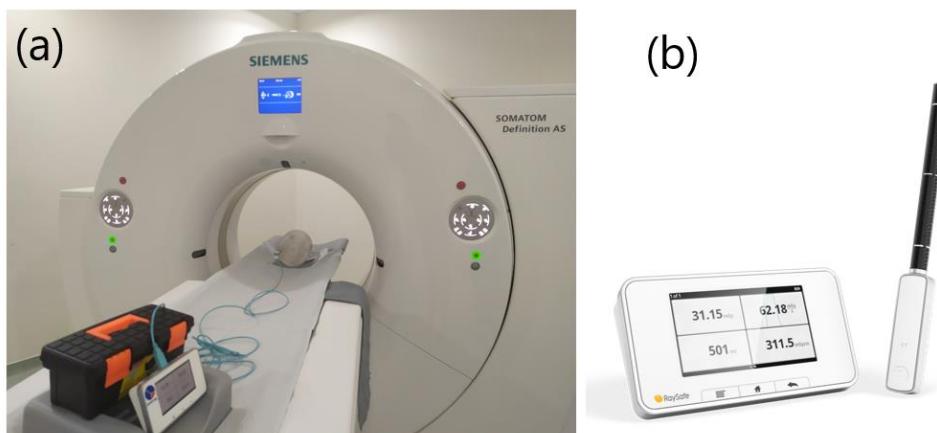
Siemens Somatom Definition AS CT scanner (2a), Raysafe X2 CT sensor (2b).
